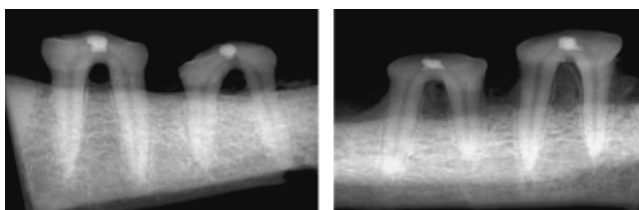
Representative radiographs of contralateral, critical-size, supra-alveolar, periodontal defects implanted with rhGDF-5/PLGA/ β -TCP (right) or the PLGA/ β -TCP carrier control (left) at 8 weeks. The rhGDF-5/PLGA/ β -TCP test sites exhibit bone formation reaching the cemento-enamel junction and displaying a periodontal ligament space *versus* more modest bone formation in the control.
